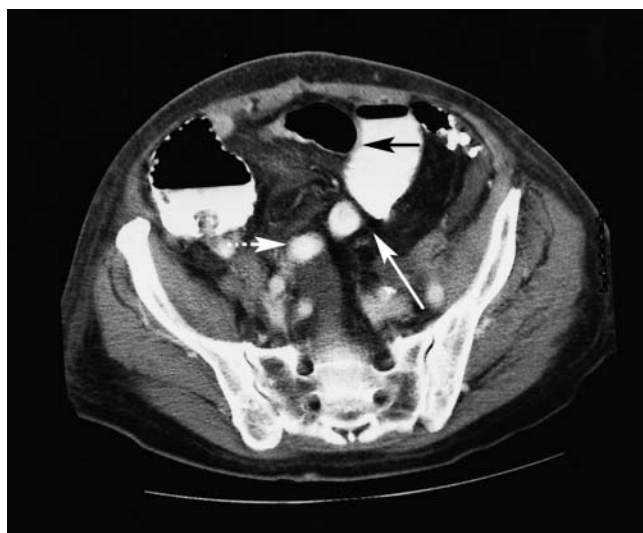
Computed tomography scan from a patient with adhesive partial small bowel obstruction shows a massively dilated small intestine (black arrow) proximal to a thick adhesive band (large white arrow) and decompressed small bowel distal to the adhesion (dashed white arrow). The patient was operated on because of the low probability that this obstruction would resolve with conservative management.
